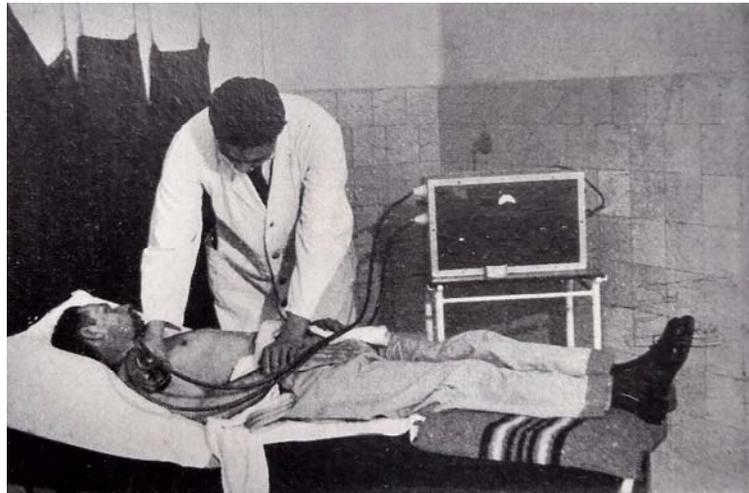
Clinical ultrasound therapy. Martin Luther Hospital Berlin. 1938. [73]
